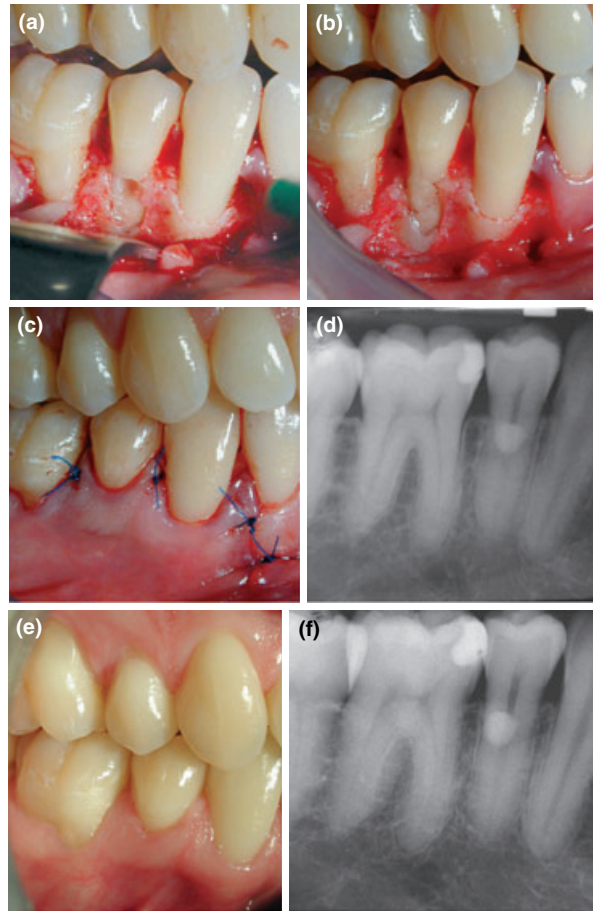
Operative management. (a) Resorptive lesion has been completely excavated; (b) resorption cavity has been restored with glass ionomer cement; (c) immediately post-treatment (d) radiograph of restored tooth; (e) clinical; (f) radiograph view at 1 year review.
